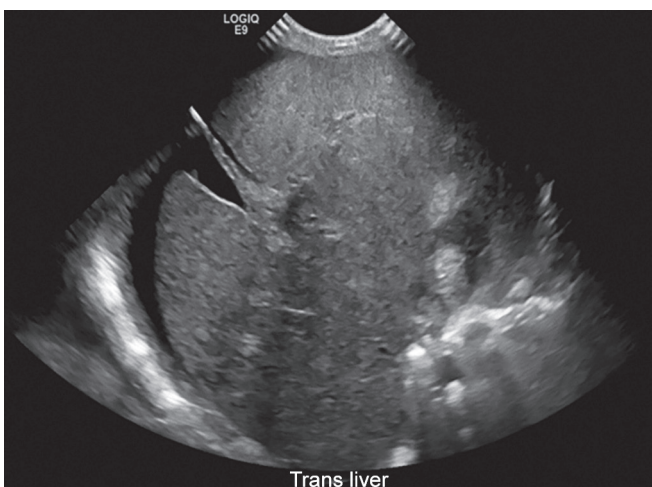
Coarse liver with ascites noted on abdominal ultrasound
